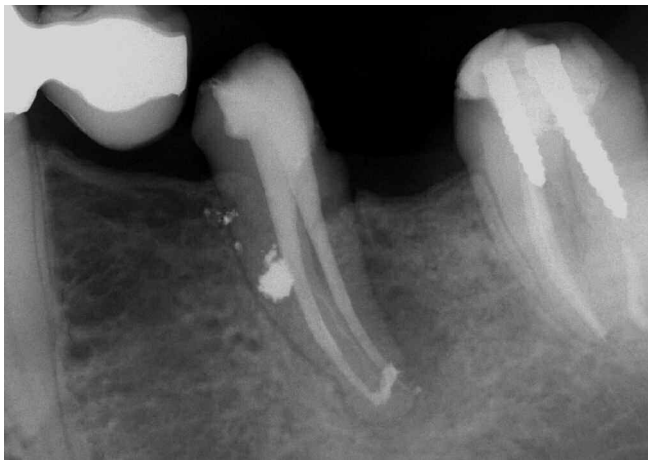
A post-treatment radiograph reveals three-dimensional retreatment. Note the third mesial system between the MB and ML canals.
